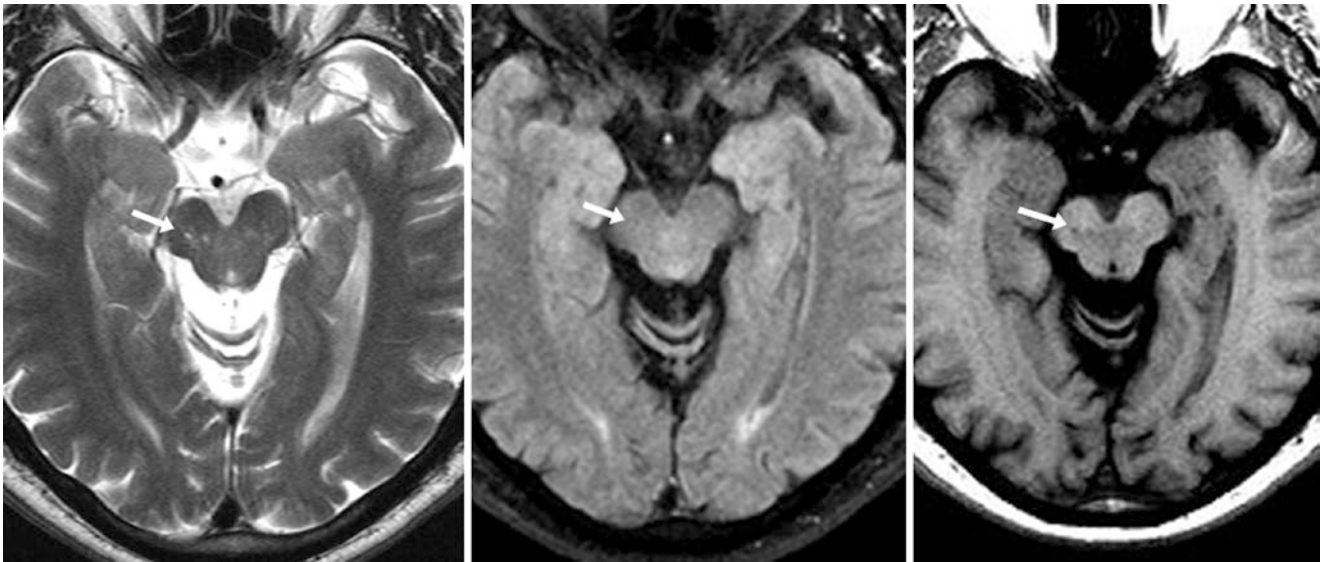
A 60 year old had tiny PVSs (*arrows*) of the right midbrain and cerebral peduncle on axial T2WI (*left*), which suppress with CSF and are nearly invisible on FLAIR (*middle*). These PVSs are also barely visualized on T1WI (*right*)
